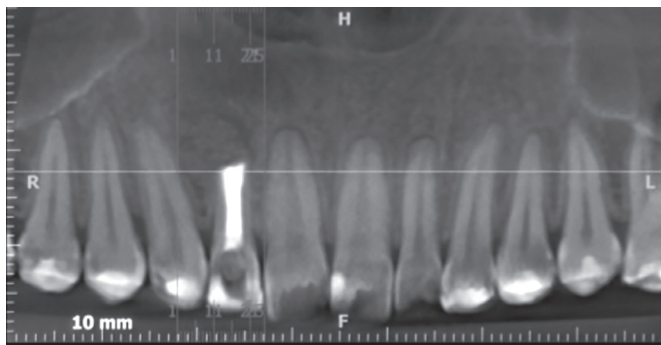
CBCT at 190 days after the surgery.
